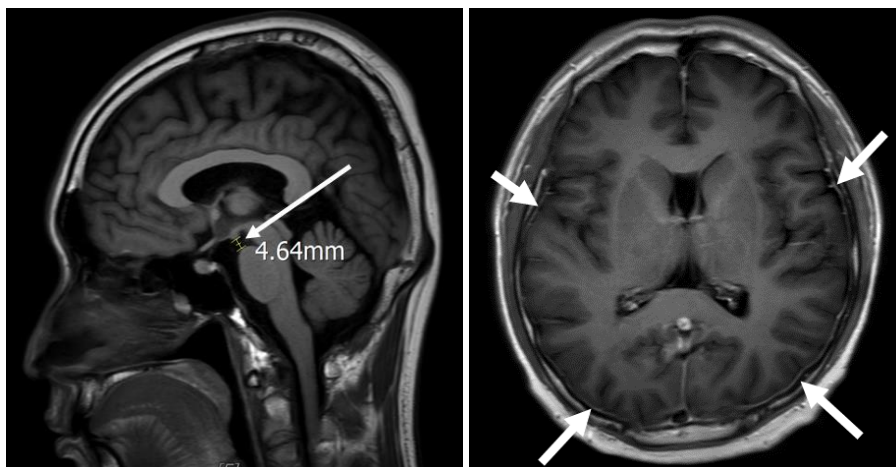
Sagittal (left) and axial (right) views of a T1 post-contrast MRI of the brain showing shorting of the pontomamillary distance(White arrow, left), pachymeningeal enhancement(White arrow, right), suggestive of SIH
